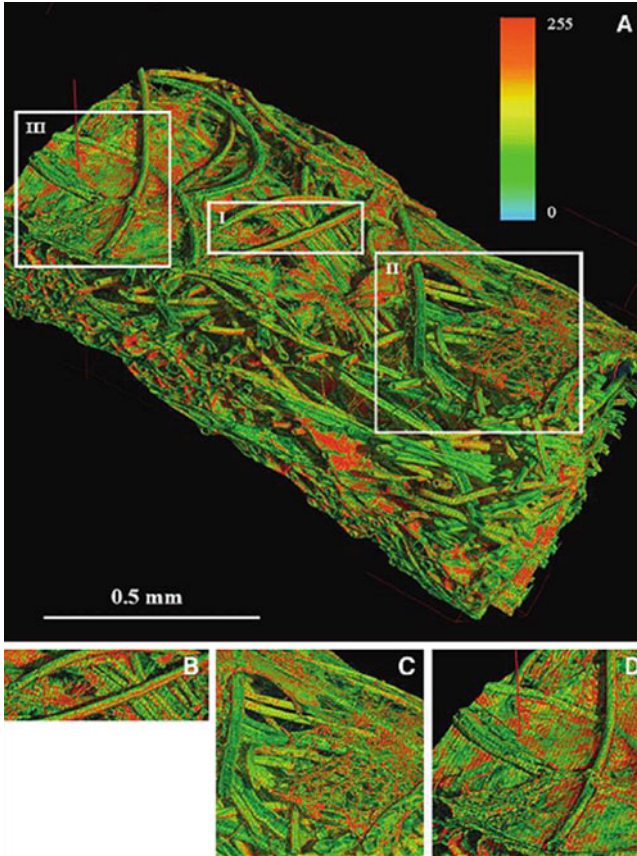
Extracellular matrix detection using X-ray micro computed tomography. 3D display of the scaffold fibers and of the deposited matrix (a). The “stages” were zoomed in. The matrix fibrils were initially deposited on the scaffold fibers (Stage I) (b). At Stage II, they appear to be organized in chains at different sites (c). At Stage III, chains appear to be organized as networks at different sites, indicating that the aggregation process contributes to developing matrix layers (d)
